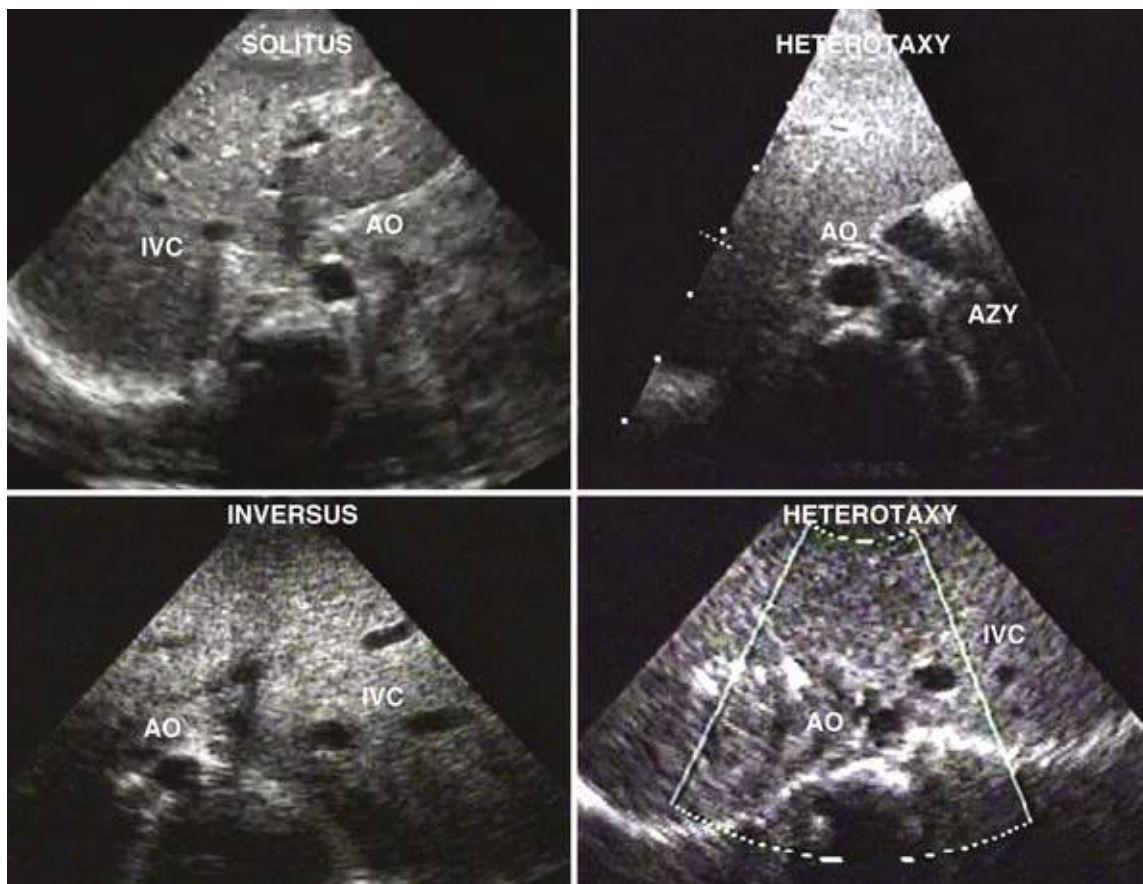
Montage of the different types of situs as seen by a subcostal echocardiographic scan. Note that situs solitus and inversus are just the mirror images of each other. The upper right picture is in the setting of heterotaxy with an interrupted intrahepatic inferior vena cava, with azygos continuation on the left. This is seen more frequently in left atrial isomerism. The lower right picture is also in the setting of heterotaxy with an intrahepatic inferior vena cava that is positioned closer to the aorta than in solitus or inversus. Note also the midline liver. This pattern is seen more commonly in right atrial isomerism. AO, aorta; AZY, azygos; IVC, inferior vena cava.
